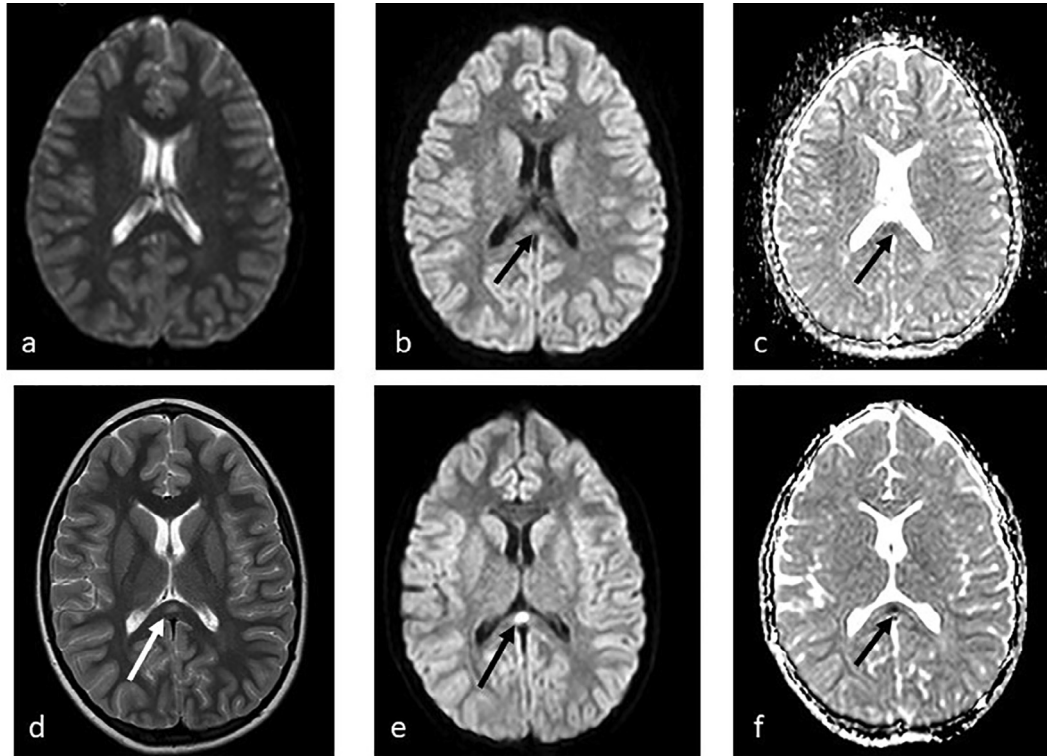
Patient 21's (Table 2) first T2 (a) and diffusion weighted MRI (b,c) reported to be normal although very slight diffusion restriction with normal T2 intensity in the splenium could be identified retrospectively. Her follow-up MRI (d,e,f) 5 days later reveals splenic ovoid diffusion restriction with T2 hyperintensity.
